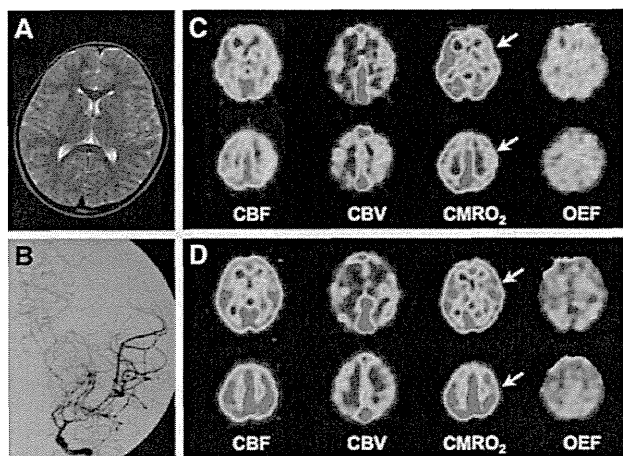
Radiological findings of a 8-year-old girl who developed transient motor aphasia. A, Preoperative T2-weighted MRI revealed no parenchymal lesion in the brain. B, Preoperative left internal carotid angiography revealed a marked stenosis of the left carotid fork and the development of basal moyamoya vessels. C, Preoperative positron emission tomographic (PET) scans showed cerebral blood flow (CBF) decrease, cerebral blood volume (CBV) increase, cerebral metabolic rate for oxygen (CMRO₂) decrease, and oxygen extraction fraction (OEF) elevation in the left cerebral hemisphere. Note a marked reduction of CMRO₂ in the left cerebral hemisphere (arrows). D, Postoperative PET scans performed 4 months after surgery revealed a normalization of all of 4 PET parameters. Note a normalization of CMRO₂ in the left cerebral hemisphere (arrows).
